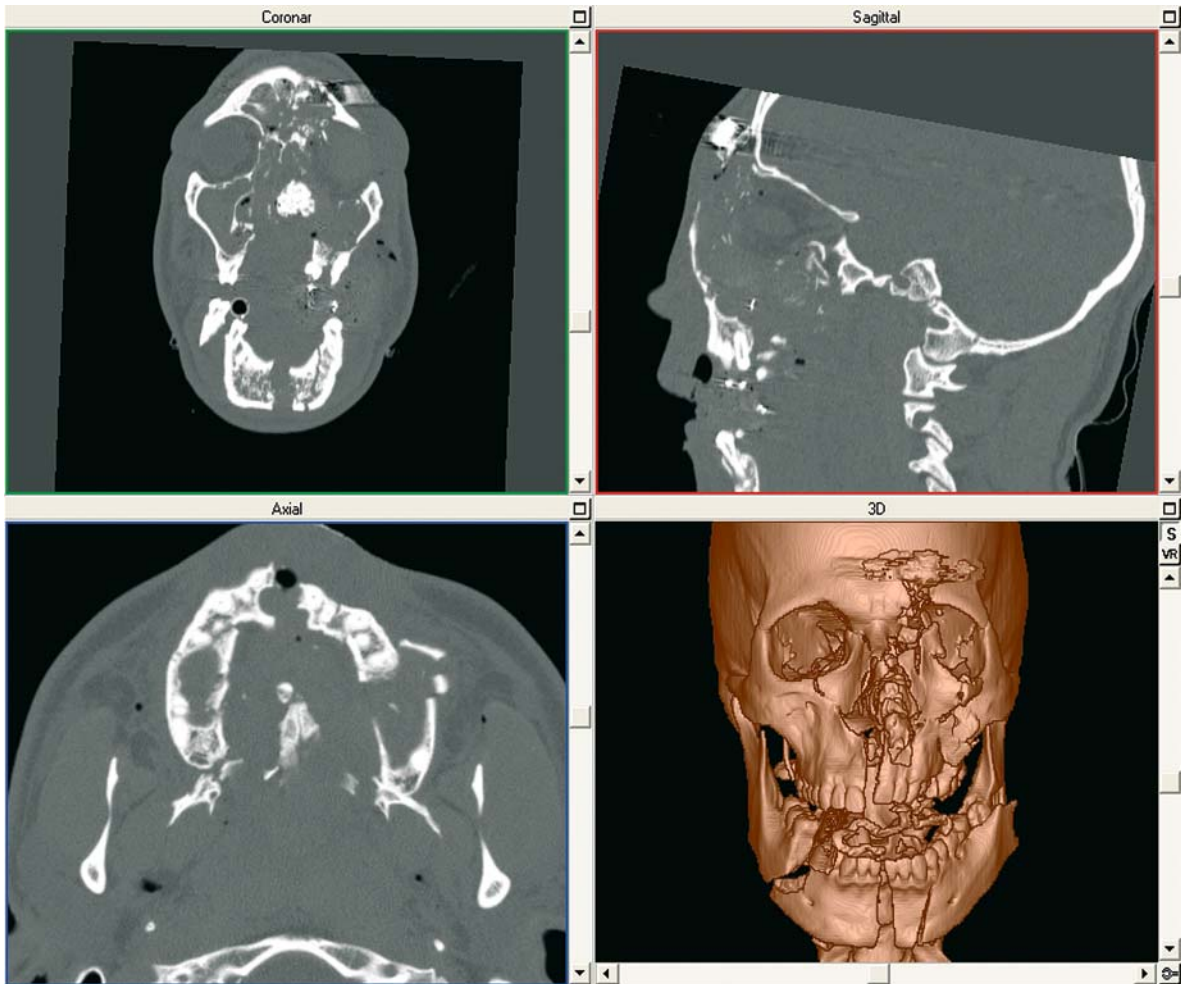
Panfacial fracture after a gunshot injury – preoperative analysis. The multiplanar display of the preoperative CT data set (corona, sagittal, axial, and 3D reconstruction) reveals the extent of the destruction
